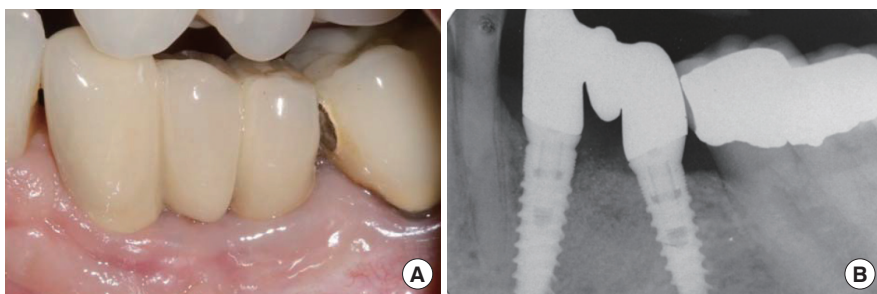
(A) Clinical presentation at 36 months after fitting the bridge. (B) Periapical radiograph 36 months after procedure completion.
